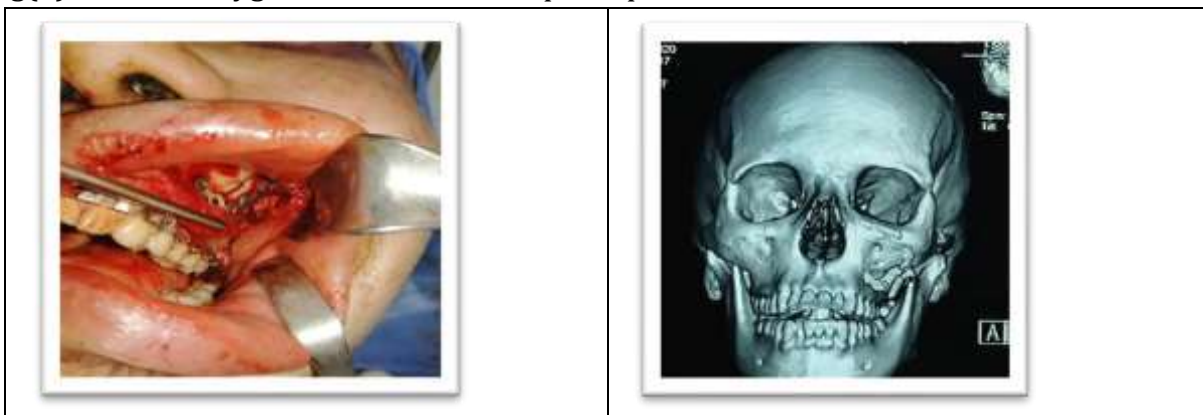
fixation of zygomatic buttress and post operative 3D CT
